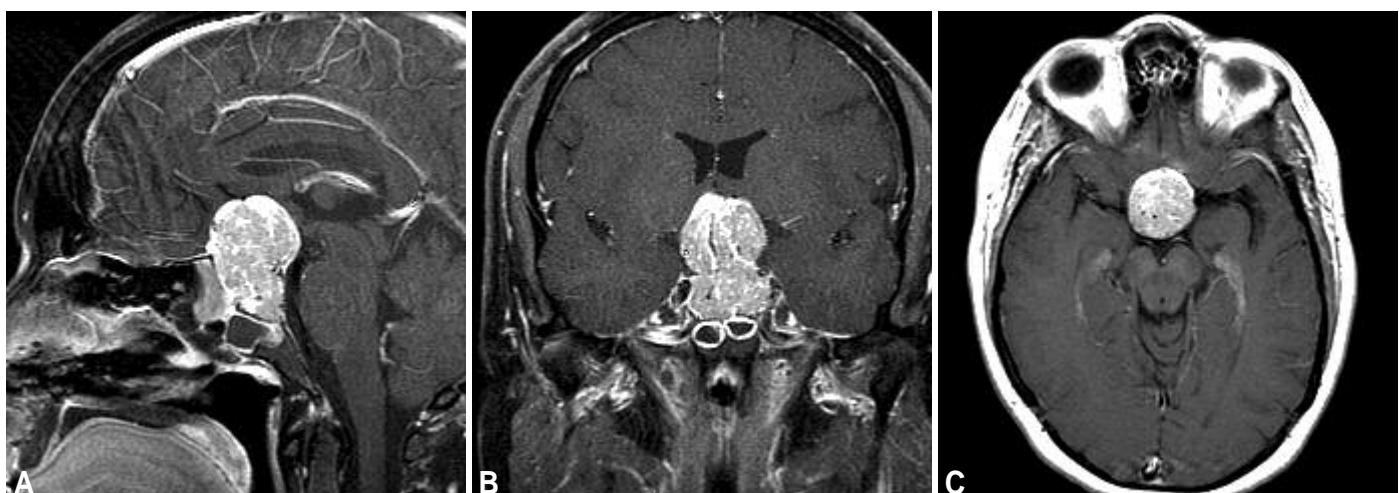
T1-weighted post-contrast MRI of a granular cell tumour in the sagittal (A), coronal (B), and axial (C) planes showing prominent contrast enhancement. Note the characteristic sellar/suprasellar anatomic location.
